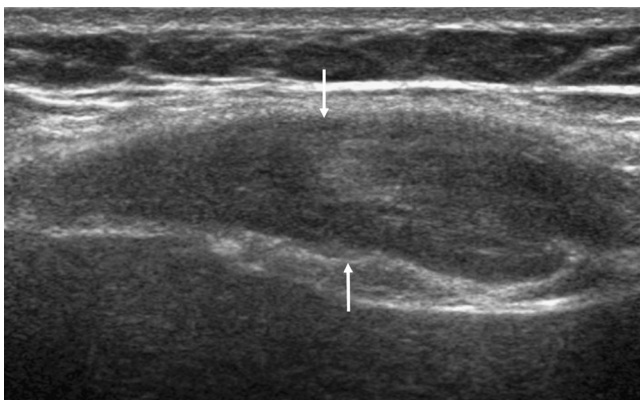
Abdominal wall fibromatosis (desmoid tumour). Transverse sonogram of the anterior abdominal wall, showing a well-defined hypoechoic lesion (arrows) with a smooth border in the muscle layer of the anterior abdominal wall. Ultrasound-guided biopsy yielded material diagnostic of fibromatosis.
